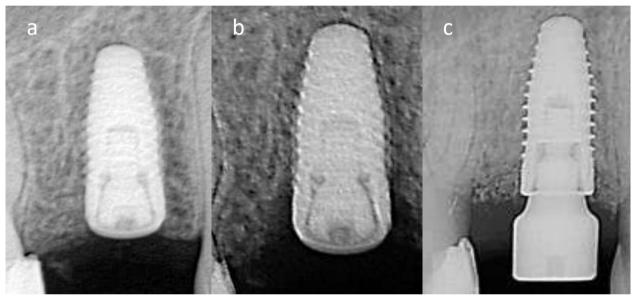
Visualization of bone healing progression through intra-oral periapical radiographs (patient B). a) Immediate postsurgical installation of implant #14; b) identification of radiolucency related to top implant segment; and c) evidence of absence of radiolucency around the implant 5 months after the surgical therapy.
